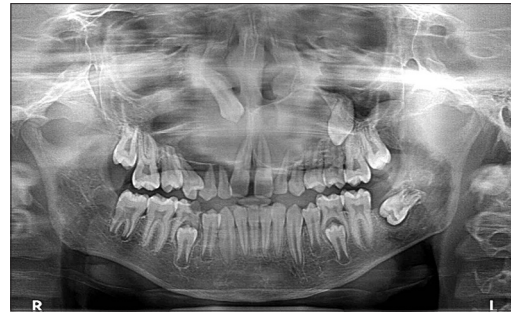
Orthopantomogram showing bilateral radiolucent lesions in the maxilla
